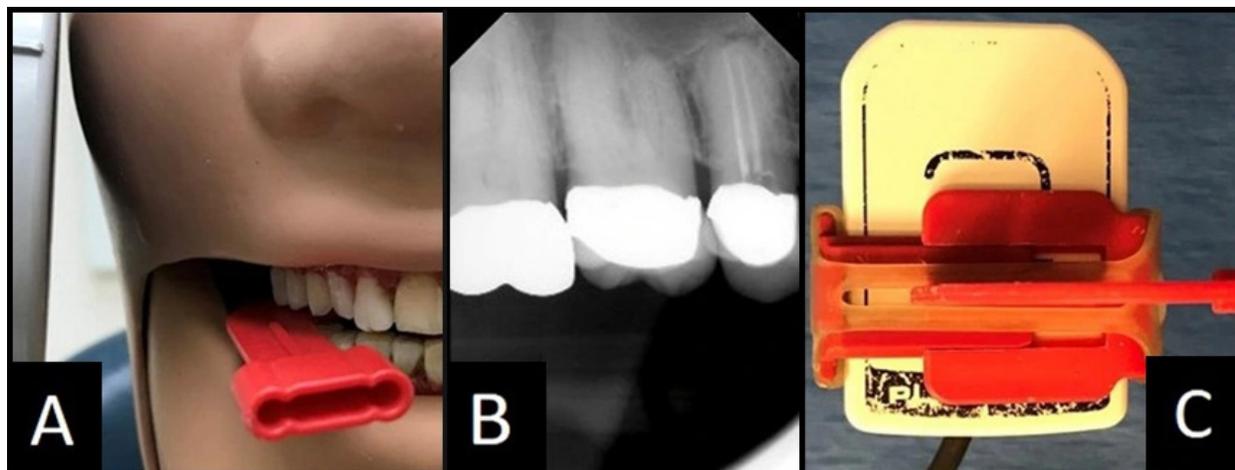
Maxillary periodontal assessment of bone levels and furcations using the vertical bitewing holder.
